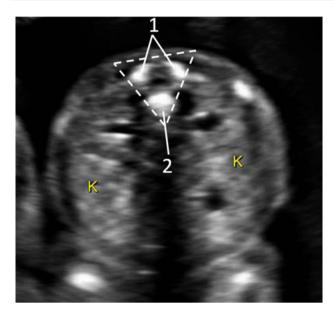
Transverse axial sonogram of spine showing (1) Ossification centers in laminae (2) Ossification centers in vertebral body
